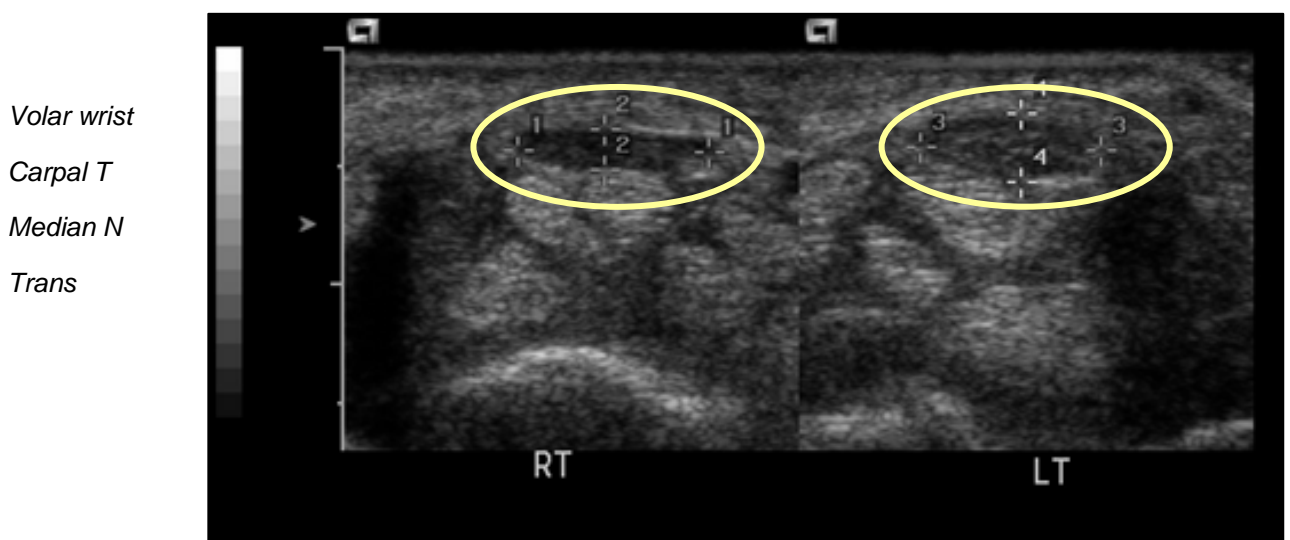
Ultrasound – Idiopathic carpal tunnel – enlarged left median nerve transverse view
